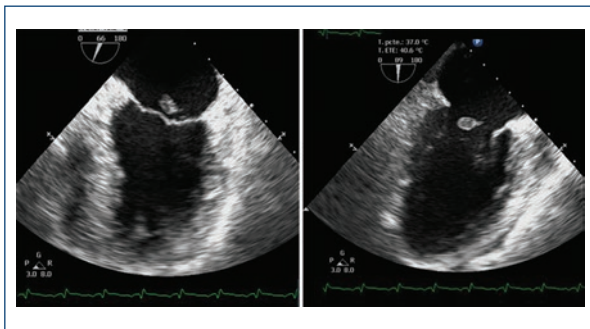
Transesophageal echocardiogram in midesophageal two chamber view showing rupture of the posteromedial papillary muscle.
